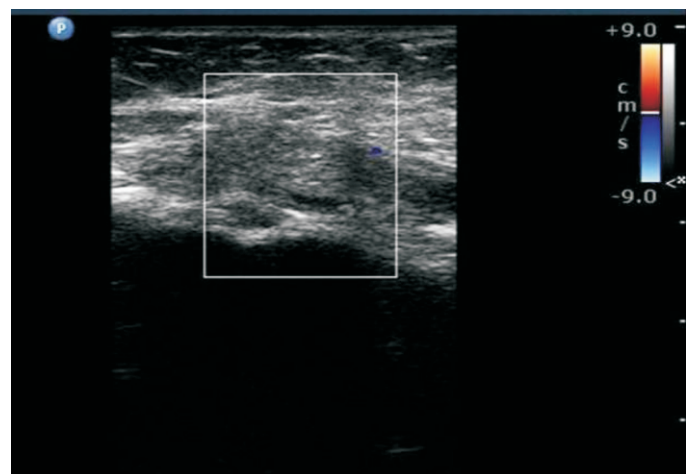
Colour Doppler study – Non- reactive
